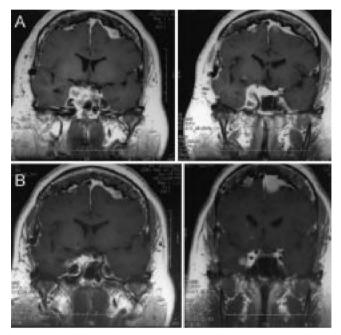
Case 11. A: Preoperative, coronal contrast-enhanced magnetic resonance images obtained in a patient with meningiomatosis and a right CS meningioma encasing the CA. B: Magnetic resonance images obtained 12 months after surgery and postoperative radiosurgery showing nearly complete regression of the residual tumor in the CS. The patient's abducent paresis improved postoperatively, prior to stereotactic radiosurgery.
